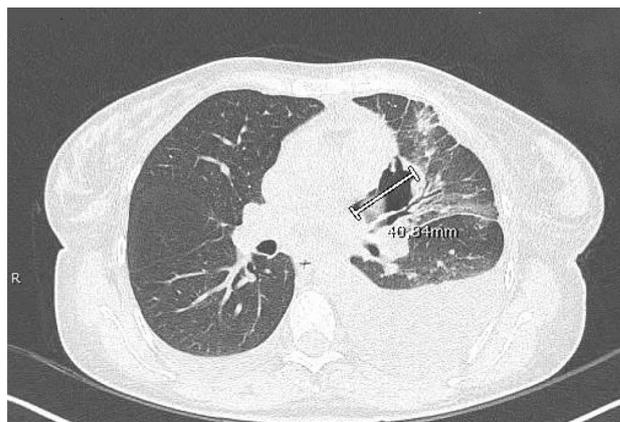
The CT scan (lung window level) shows, adjacent to the right pulmonary artery and to the lingular bronchus, a gas collection (diameter of 4 cm) bounded by the pericardial layers
